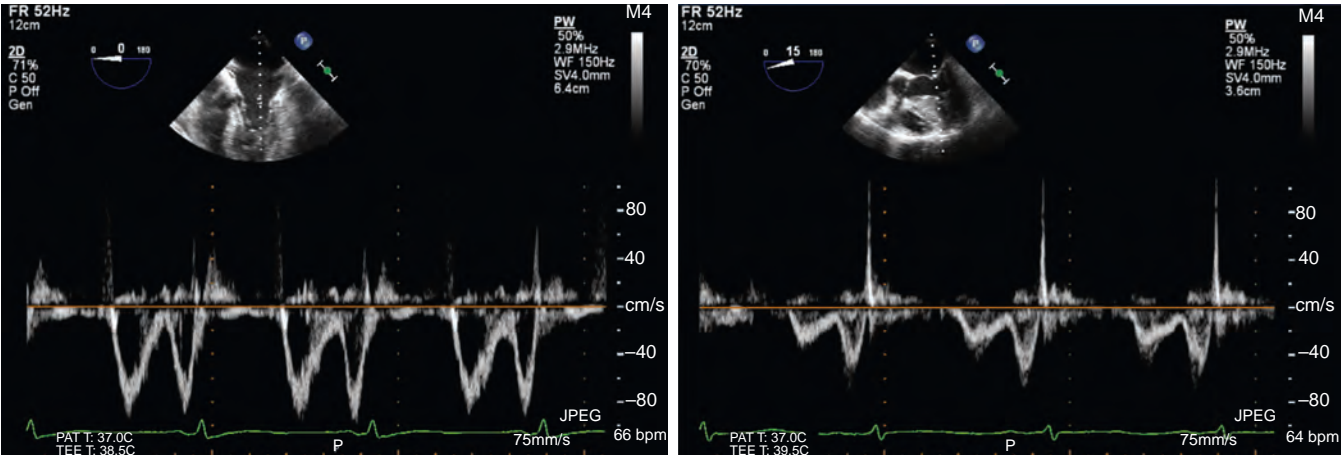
Transmitral blood flow velocity waveforms obtained using pulsed-wave Doppler echocardiography under normal conditions (left) and during delayed relaxation (right).
